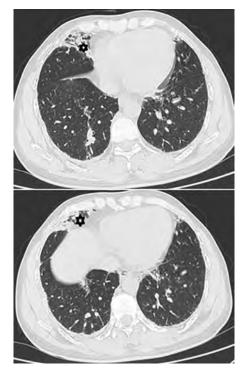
High-resolution computed tomography (HRCT) chest was performed 7 days postingestion of paraquat which revealed multiple focal areas of fibrosis with cystic lucencies involving the medial segment of right middle lobe (RML), lingula, and posterobasal segment of right lower lobe (RLL) as described
